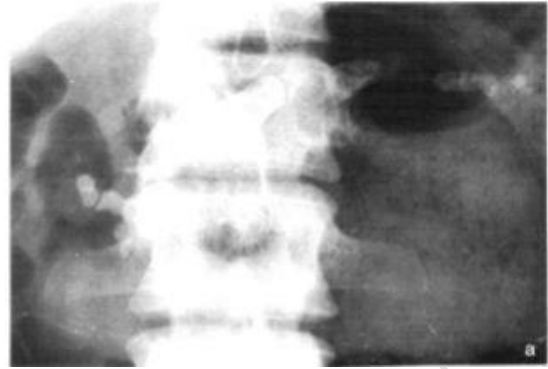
A plain x-ray of the abdomen shows gr. III calcification.
